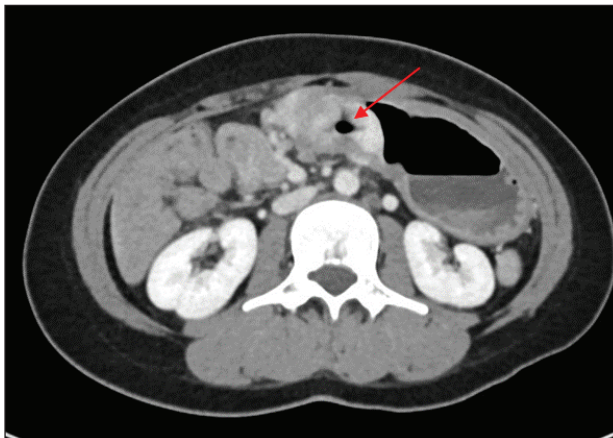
CT graphic polypoid mucosal wall thickening at the distal antrum and pylorus.
